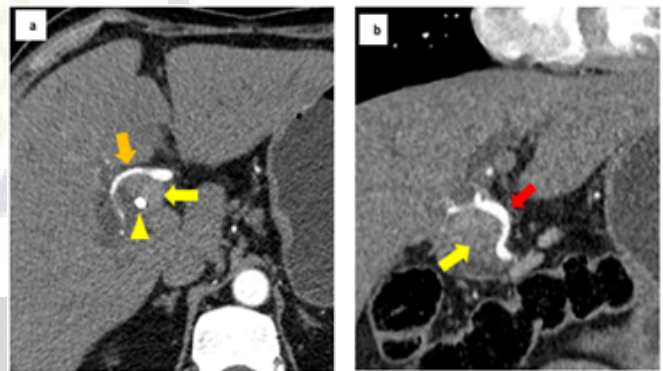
Axial (a) and coronal (b) sections of CT arterial phase images showing distal intraductal growing type of cholangiocarcinoma (yellow arrow) in a patient having long standing CBD stent (yellow arrow head). There is involvement of common hepatic (red arrow) and right hepatic (orange arrow) arteries by the tumour.
